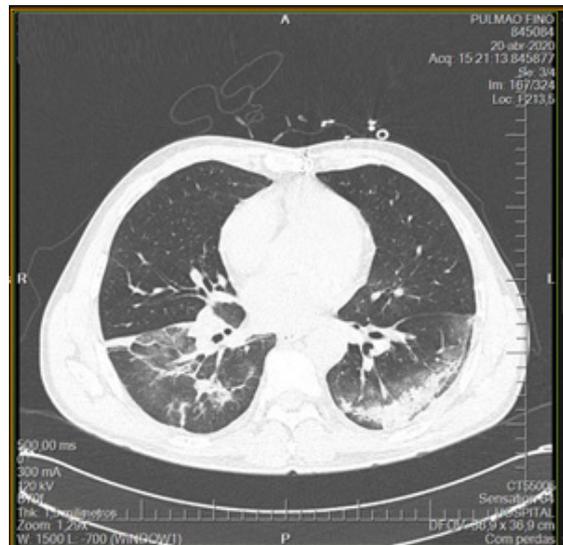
Case 1 - Computed Tomography of the Chest.
